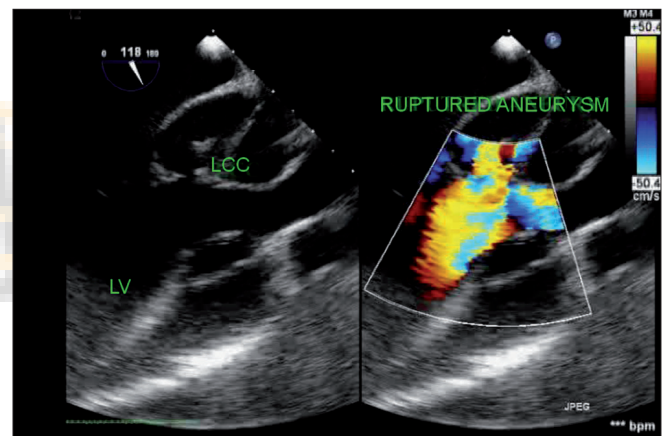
Mid-esophageal aortic long axis color Doppler view showing ruptured aneurysm from left coronary sinus into left ventricular cavity. LCC: left coronary cusp; LV: left ventricle
